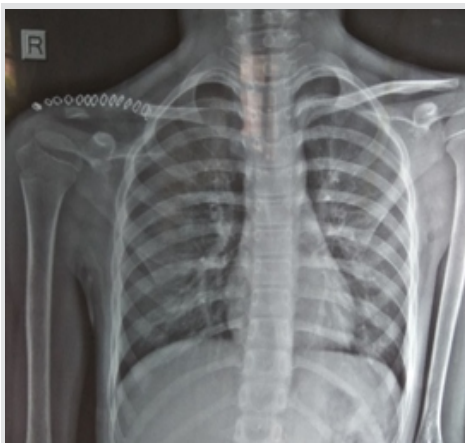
Post-operative X-ray showing marginal excision of the tumor.
